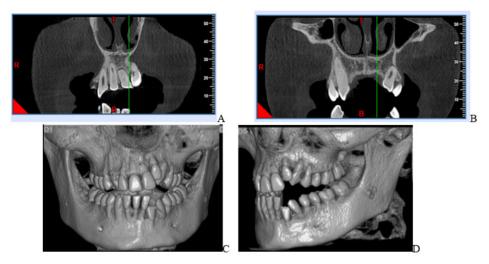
Radiography. A: Morphology of central roots B: Inclination of upper teeth. C: Three-dimensional reconstruction.
